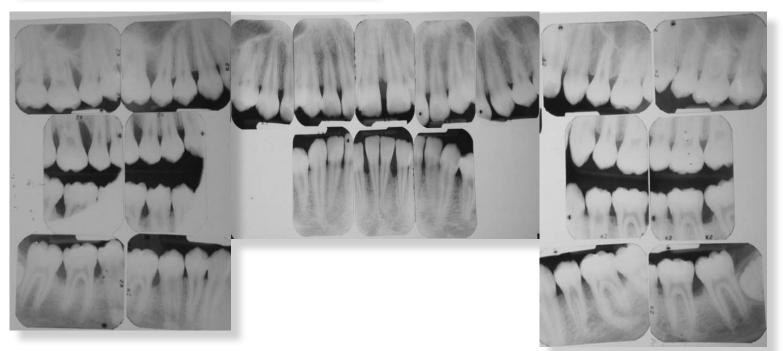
Aggressive periodontitis. Full mouth radiographic survey of the 13-year-old patient above shows a significant loss of alveolar bone around the maxillary and mandibular incisors (anterior), and the molar teeth (specifically the first molars in both the maxilla and mandible). This is a distinguishing feature of aggressive periodontitis. The loss of bone in the anterior maxilla explains why the patient experienced drifting between his incisor teeth. Aggressive cases of periodontitis usually have marked familial aggregation. Photo source: Bruce Mandel. Used with permission.
